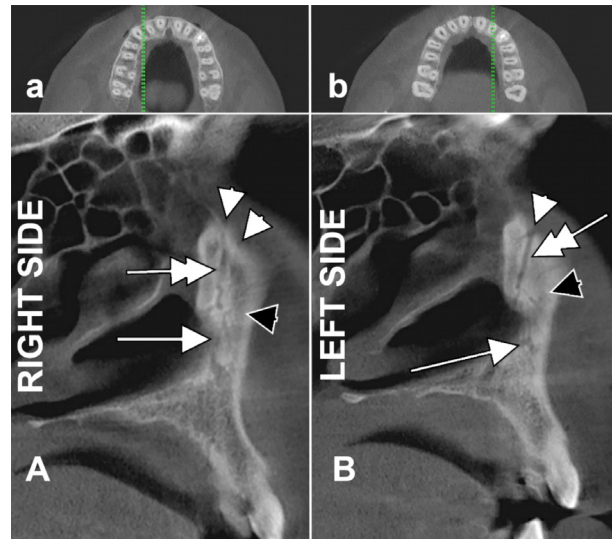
CBCT multiplanar reconstructions. On axial slices (a and b), the sagittal cuts are located in the sites of the premaxillary sutures. On sagittal slices (A and B), there are demonstrated the canals contributing to the network (black arrowheads) within the frontal processes of the maxillary bones. The foramina of Macalister (white arrowheads) are the upper openings of the Parinaud's canals (double-headed arrows). These later, as well as the canals of Wood Jones (arrows) contribute the anastomotic network within each frontal process. CBCT: Cone-beam computed tomography.
